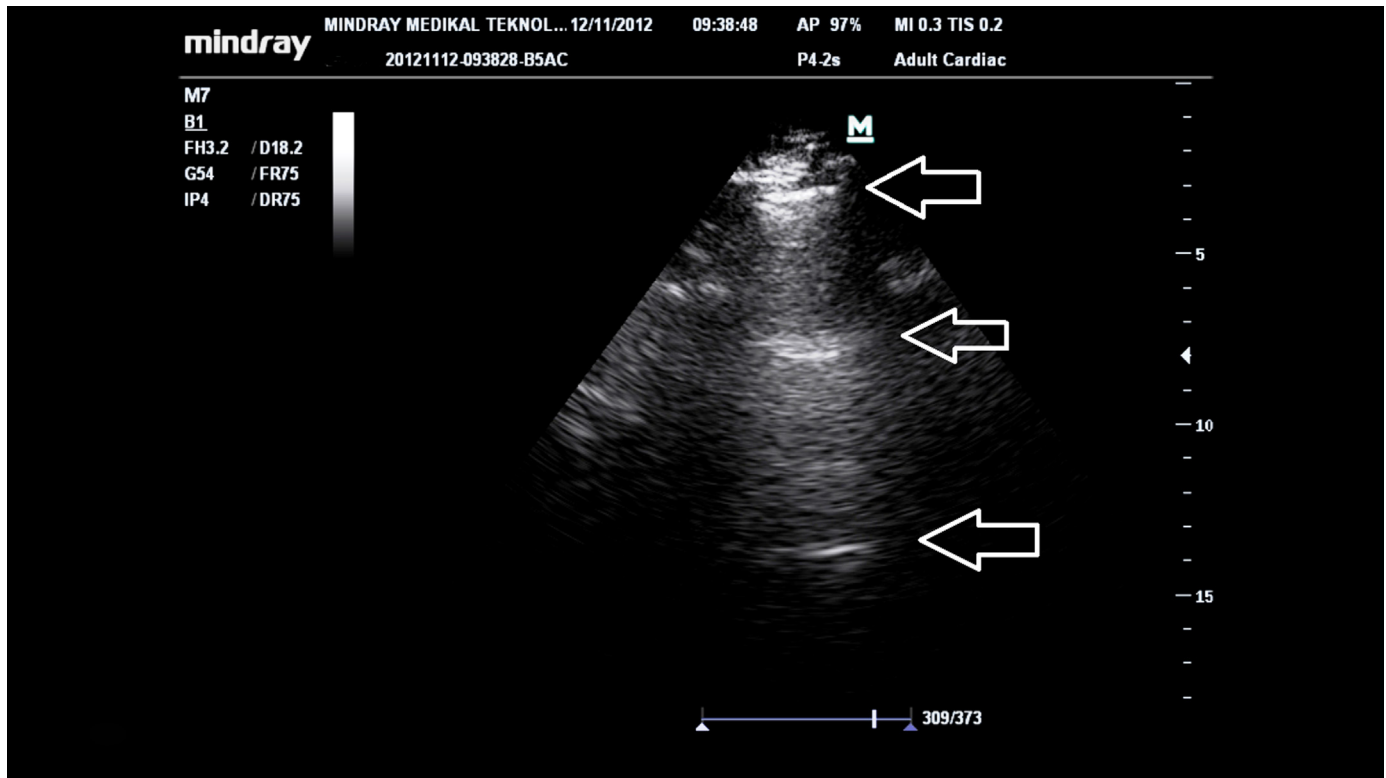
Sonographic visualization of A profile. White arrows show the horizontal hyperechoic lines parallel to the pleural line present on each hemithorax which is called A-line.
